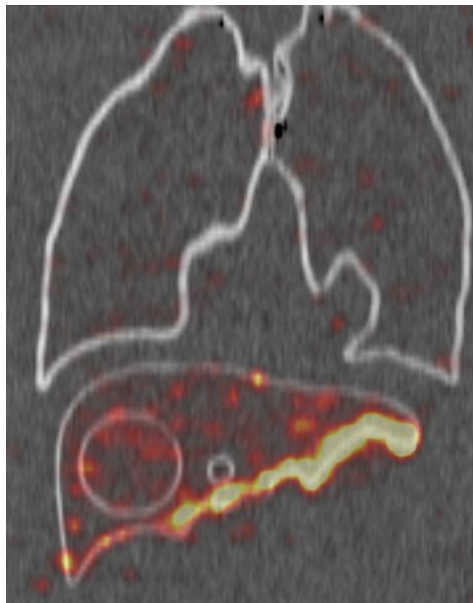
Visualization of radiation activities of lung and liver models with CT.
